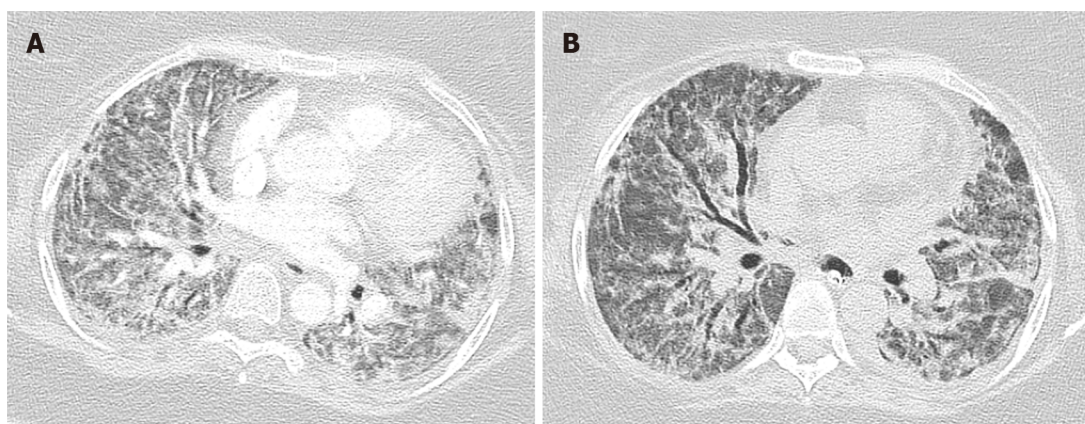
Computed tomography of the chest proliferative and fibrotic phase. A: Bilateral reticulations in proliferative phase; B: Bilateral fibrotic change in fibrotic phase.
